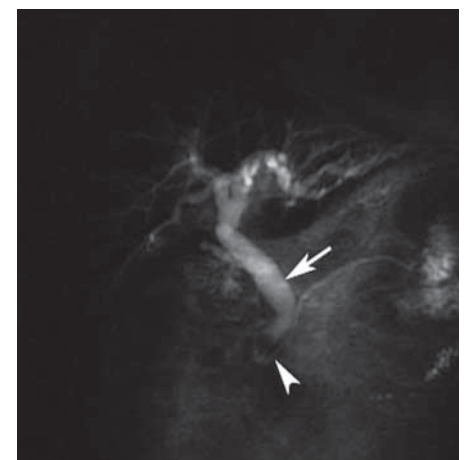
Thick slab T2-weighted magnetic resonance cholangiopancreatography. Arrow indicates dilated common bile duct. Arrowhead indicates filling defect, confirmed to be gallstone at endoscopic retrograde cholangiopancreatography.
